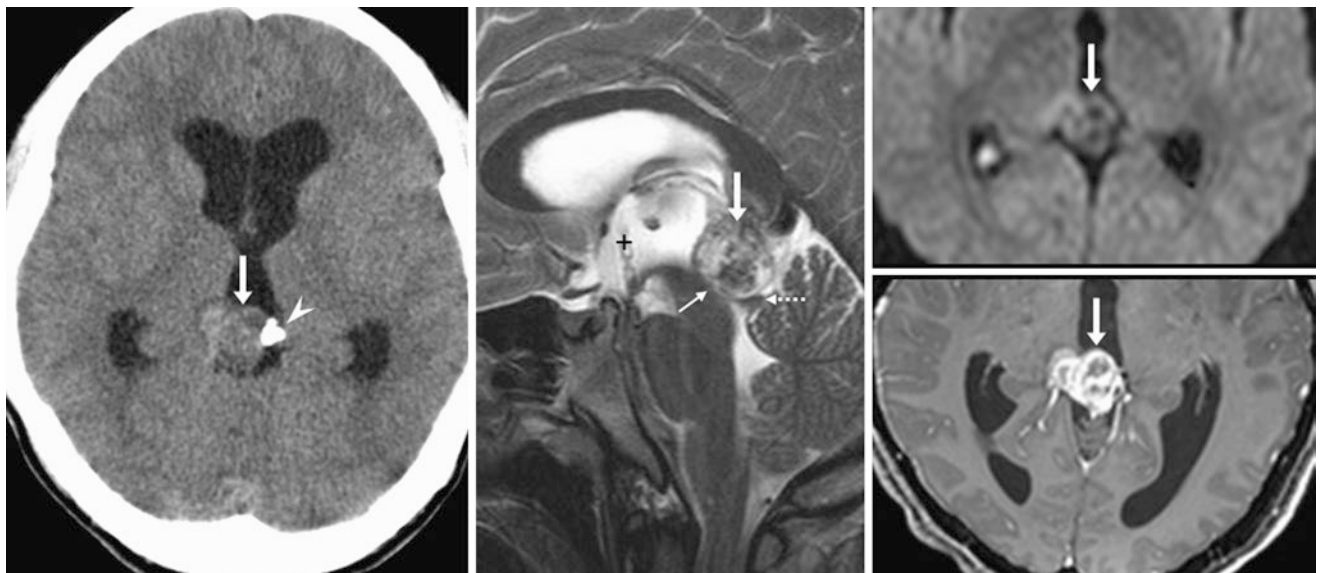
Comparison case of germinoma: a 17-year-old patient with a sizeable pineal mass (*arrows*) on NECT (*left*), which displaced a calcification peripherally (*arrowhead*) and caused hydrocephalus by compressing the tectum (*thin arrows*) and subsequently the cerebral aqueduct, as depicted on a 3 T sagittal T2WI MRI (*middle*). Note a third
